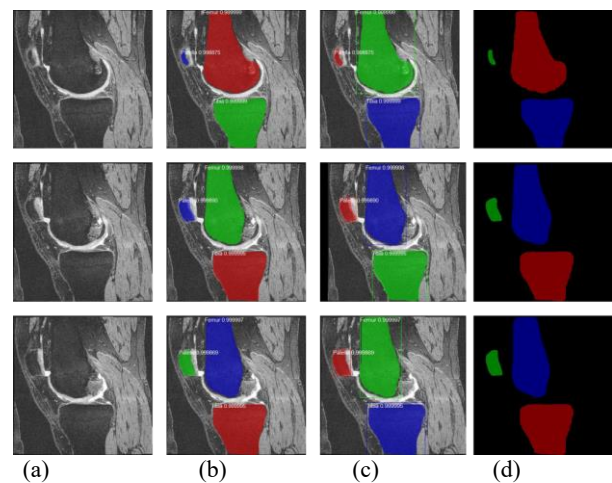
Femur, patella, and tibia bones segmentation using the Mask RCNN. (a) MR-image sequence, (b) Bone mask with a class label for MR image, (c) Mask RCNN output for MR image, and (d) Bone mask with a background
